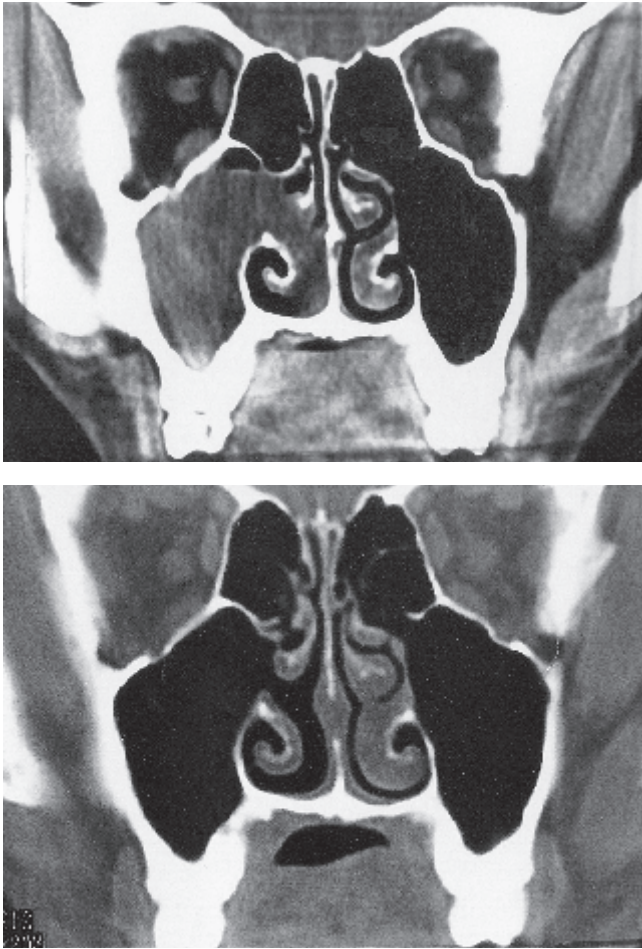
Coronal CT-scans from a 25-year-old male patient before (a) and 8 months after FESS (b). A: ACP originating from the cyst of the right maxillary sinus; B: complete normalization of the sinus mucosa, antral window in the middle meatus is patent.
